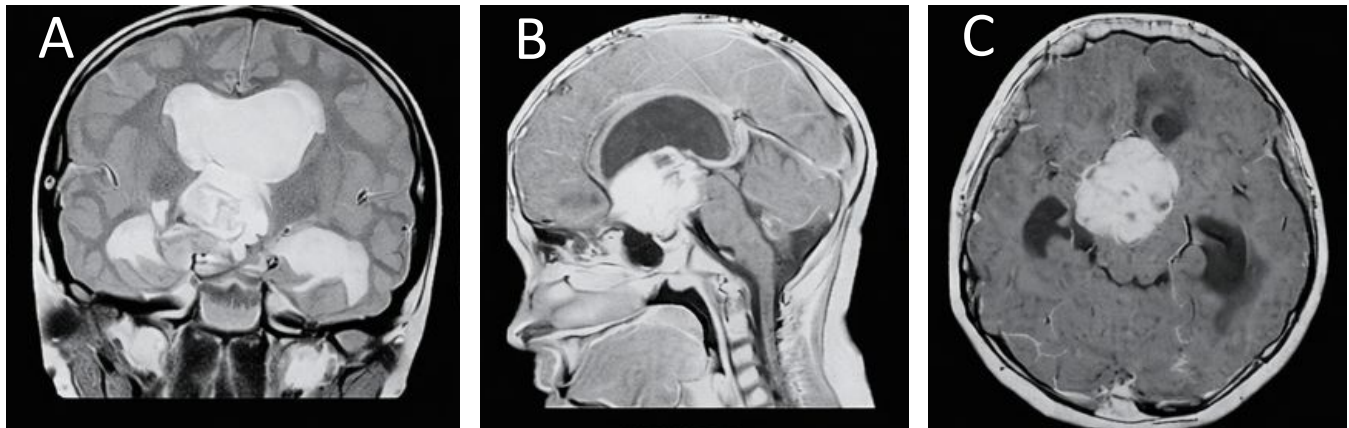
Preoperative contrast-enhanced MRI of the brain. Volumetric formation of the chiasmatic-sellar region with supra-, retro- and antisellar spread and a pronounced intraventricular component filling the third ventricle and causing occlusive hydrocephalus is visualised. Heterogeneous contrast enhancement is noted. A — frontal, B — sagittal, C — axial slices.
